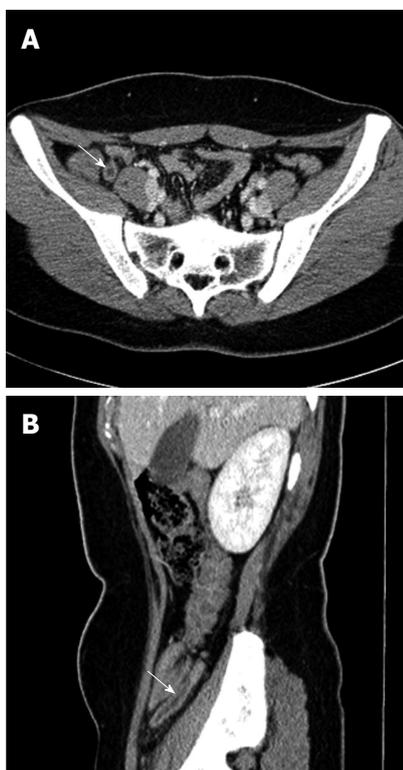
Enlarged appendix and appendiceal wall enhancement. A: Cross-sectional (arrow); B: Sagittal abdominal computed tomography scans showing increased appendiceal diameter (≥ 6.0 mm) (arrow).
